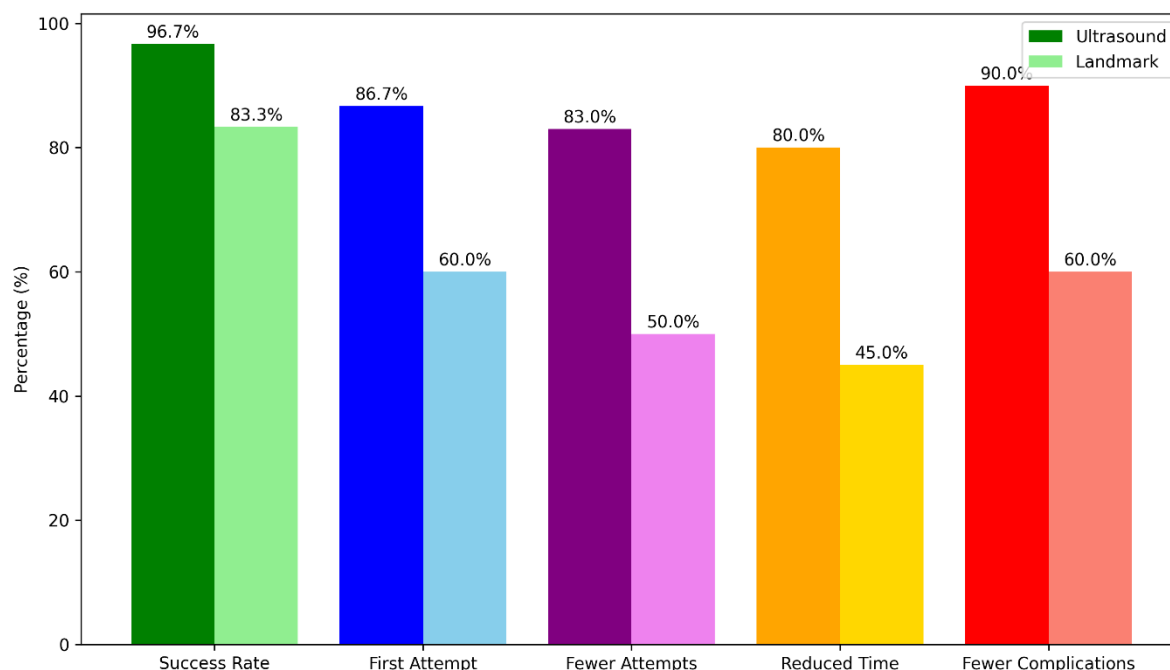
Comparison of Ultrasound Vs Landmark Technique Outcomes
